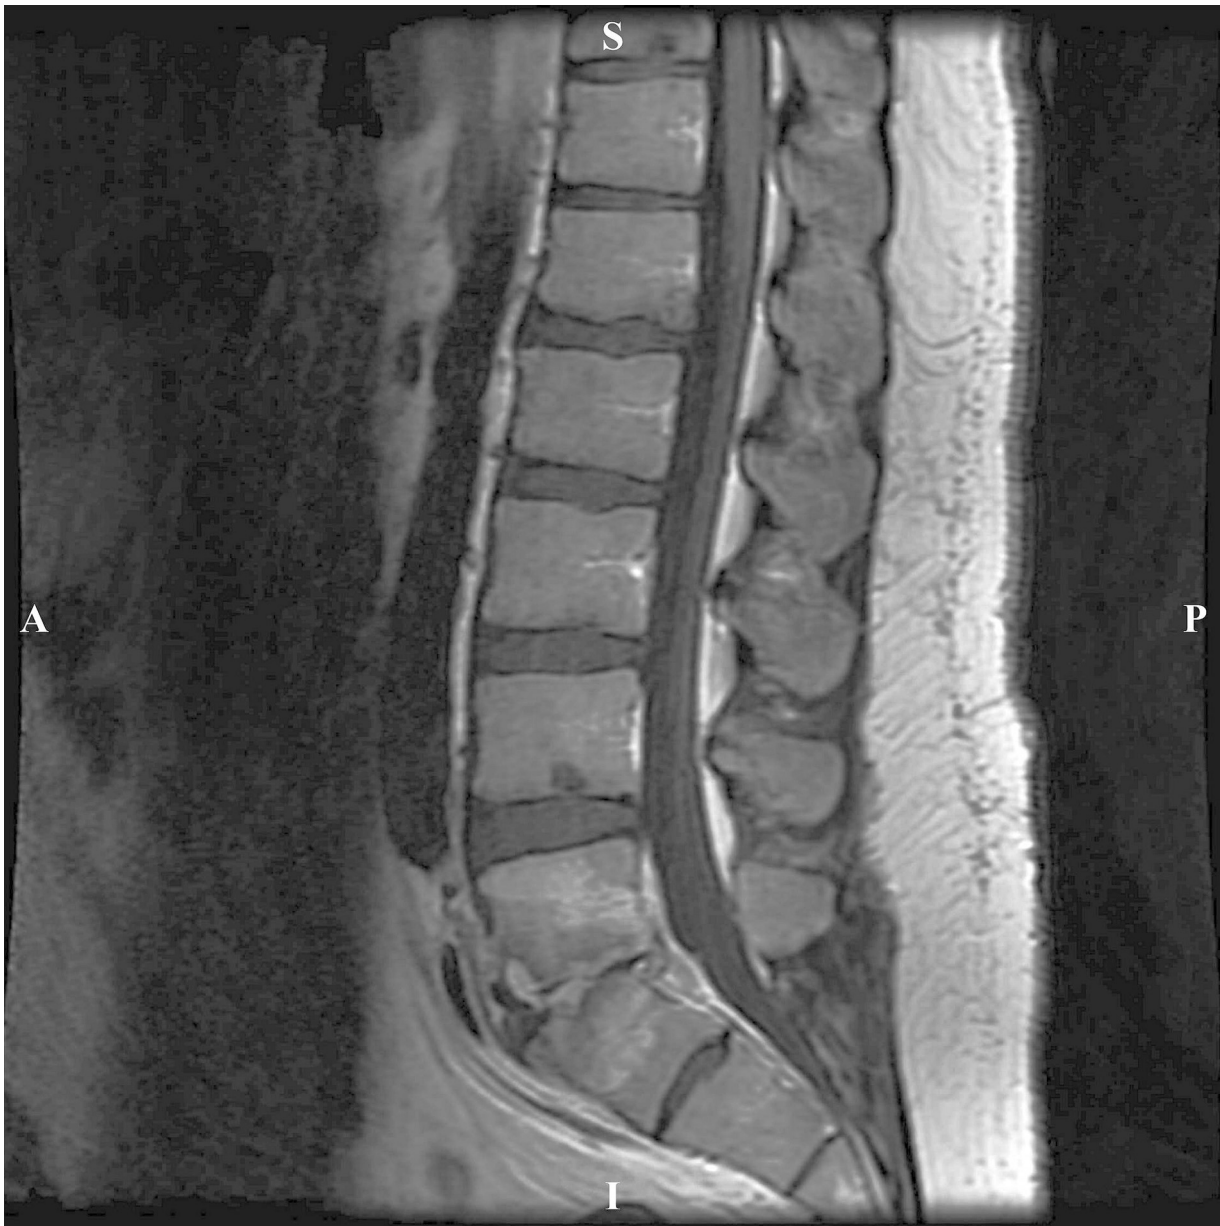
Case 2: Contrasted pre-op MRI showed contrast enhancement within the L5-S1 disc space, with advanced disc space collapse and vertebral body edema, consistent with discitis.
